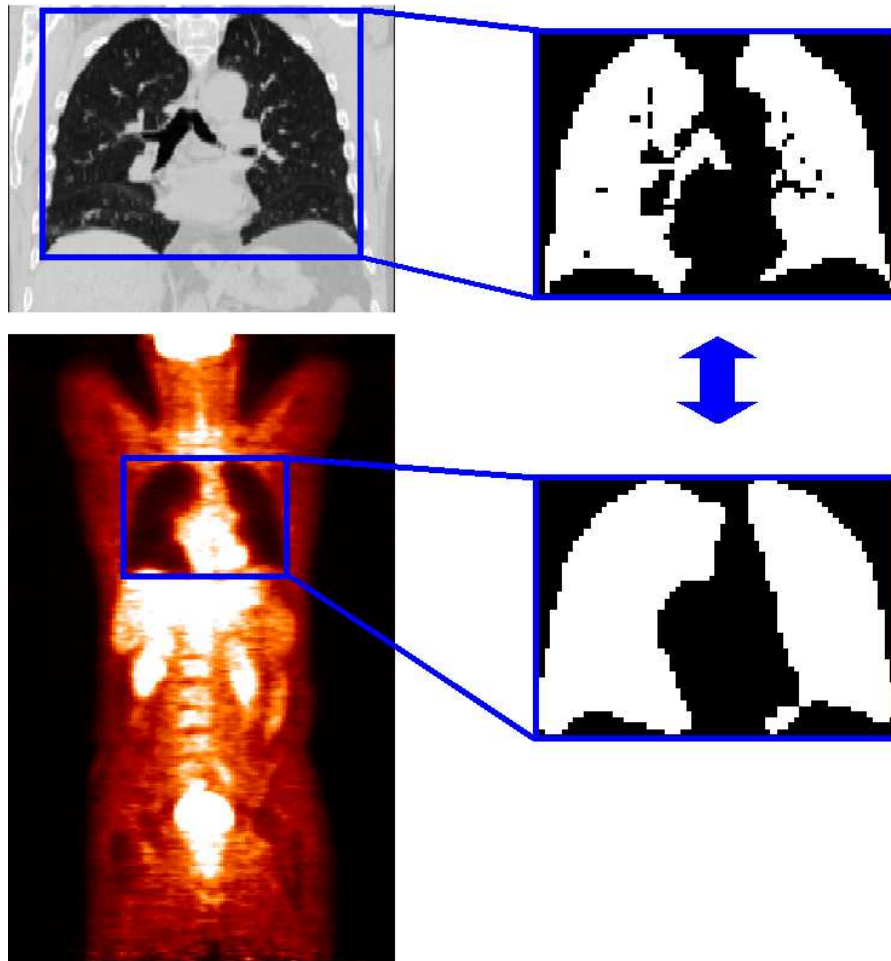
Example of different fields of view and bounding boxes computed around the structures. Left: original CT (top) and PET (bottom) images superimposed on the bounding box computed from lung segmentation. Right: input of the lung structure registration stage.
